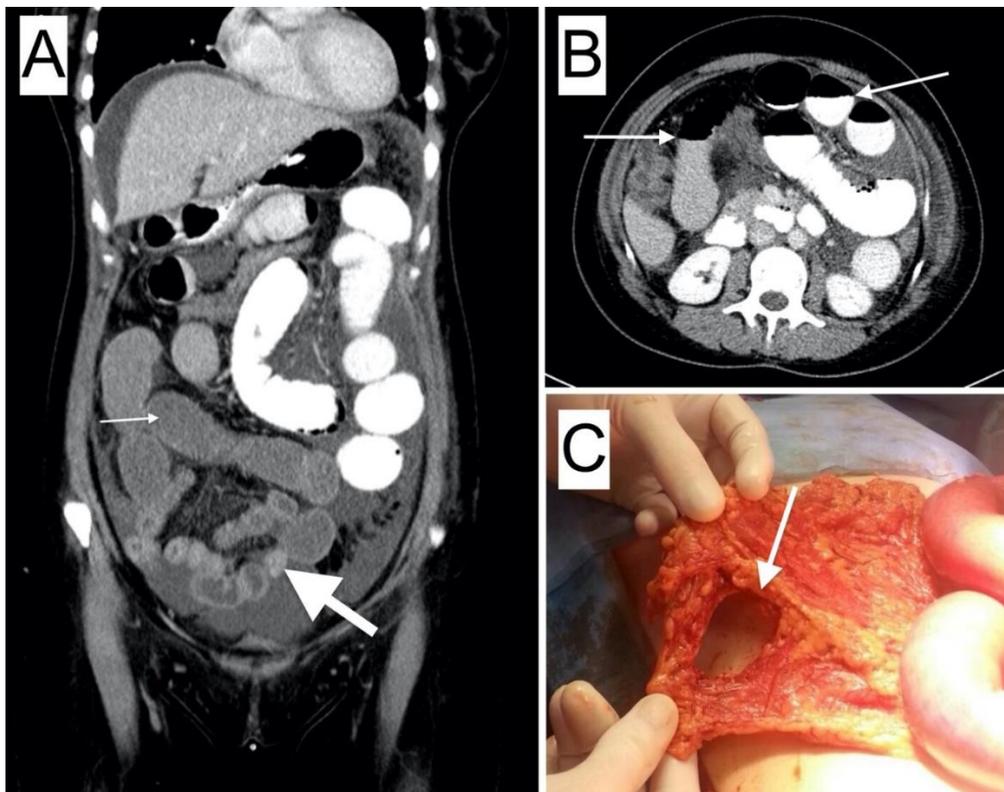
A Coronal image of the abdomen CT scan showing dilated (thin arrow) and collapsed (thick arrow) small bowel segments, oral contrast material filled bowel loops
